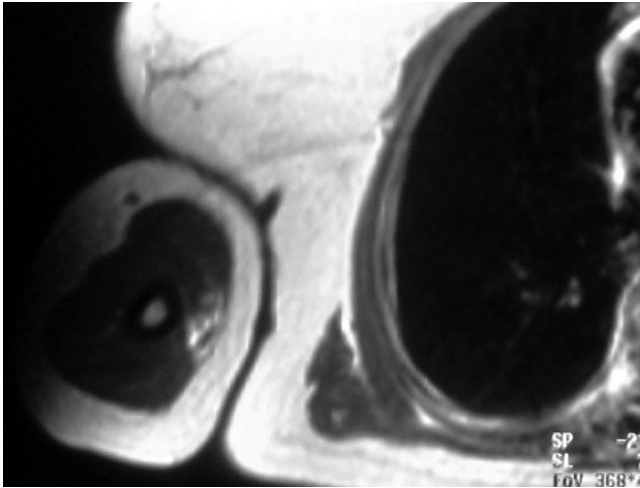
Magnetic resonance imaging with gadolinium enhancement revealed a well defined mass in the right arm.
